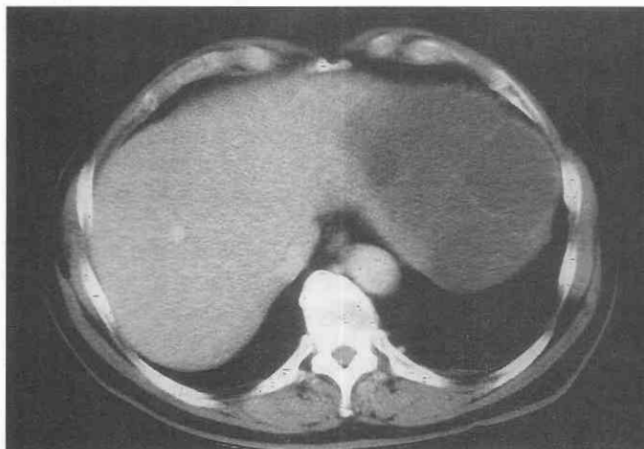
Multiloculated lymphangioma in the upper pole of the spleen, incidentally noted on a chest CT scan.
